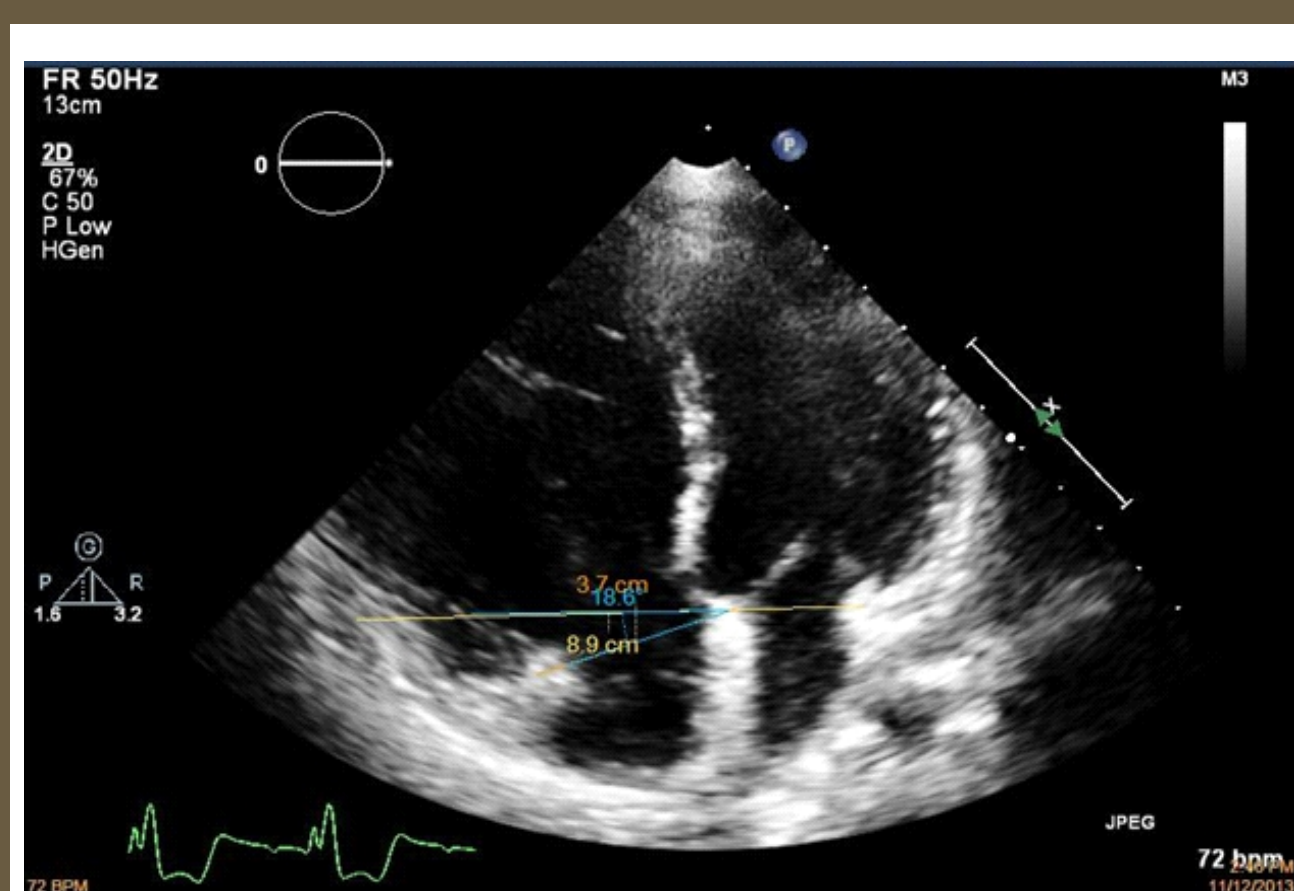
Apical four-chamber view of a patient with severe RV dilation at end-diastole. A line is drawn from the mitral valve plane at its hinge points (white). A second line is drawn from the tricuspid valve free wall hinge point to the IVS at the initial lines bisecting point (yellow)
